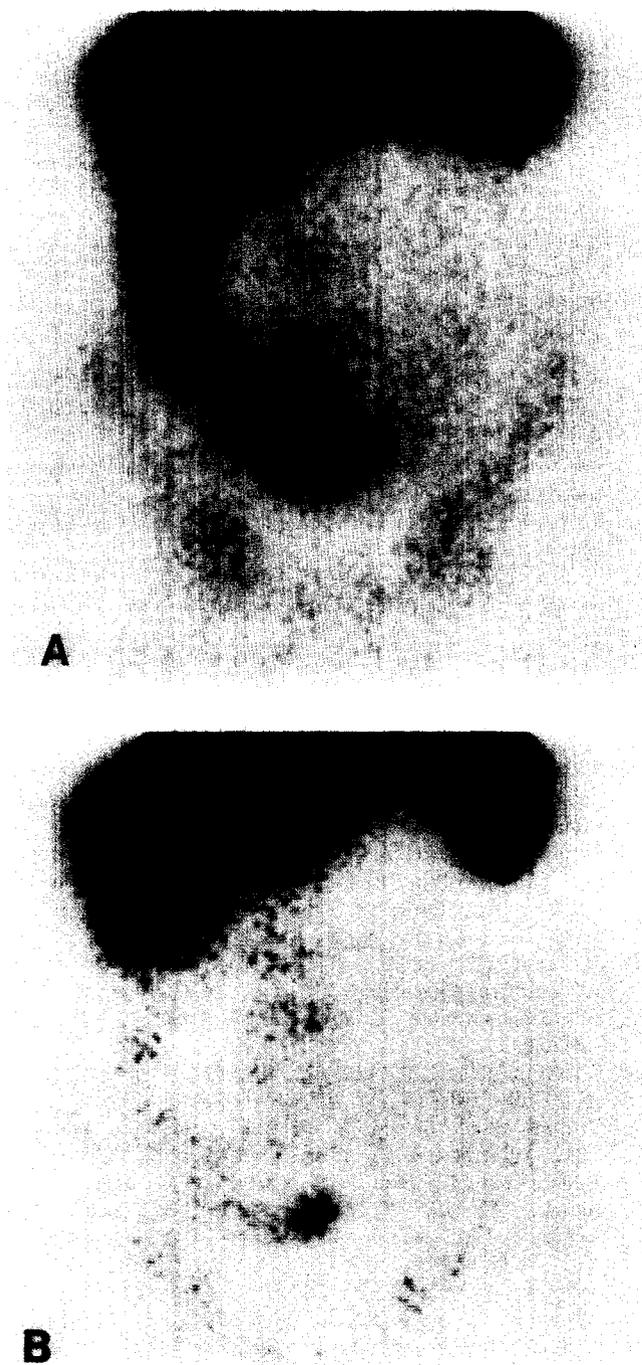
A. Pretreatment abdominal scintigraph of a patient with active Crohn's disease showing intense activity in the right iliac fossa representing ileocecal inflammation.
